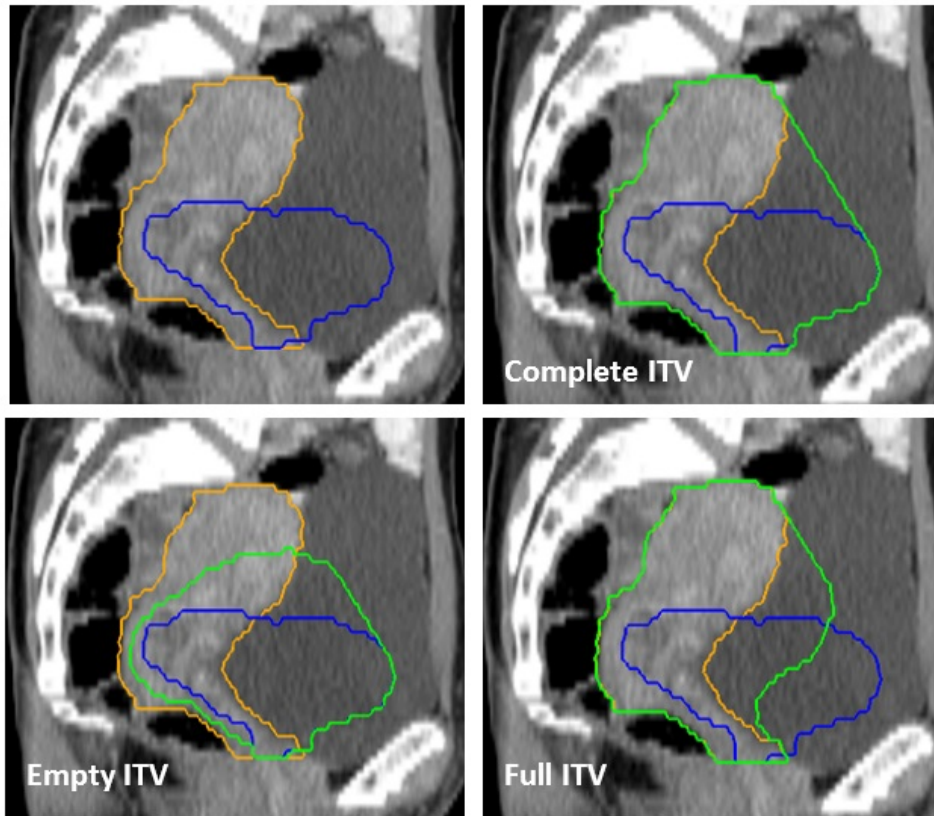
An example of the ITV structures, shown in sagittal view. Top-left shows the cervix-uterus corresponding to the empty bladder CT scan in blue, and the cervix corresponding to the full bladder CT scan in orange. Top right shows the Complete ITV in green. Bottom left and right show respectively the Empty ITV and Full ITV in green. Originally published in the [Supplementary Materials](#) (figure S2).
